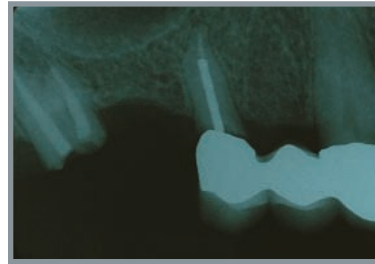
Pre-operative Radiograph; First premolar with recurrent decay and root fracture and second molar to be extracted.
